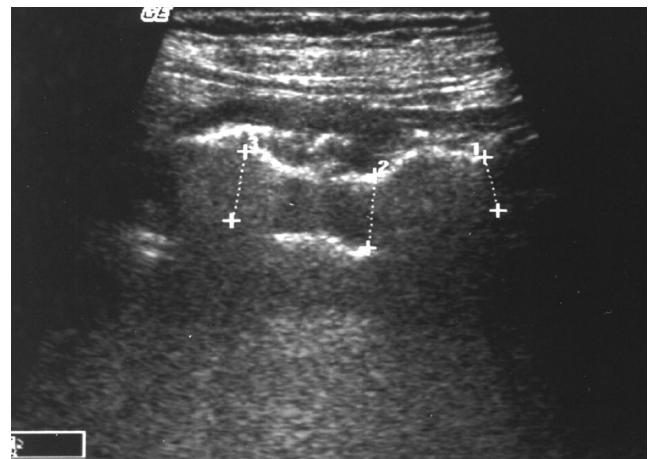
Transverse sonography shows diffuse gastric wall thickening (mean thickness, 11.2 mm) with disruption of the stratification of gastric wall. The gastric antrum of this patient was identified as gastritis in the immediate endoscopy.
